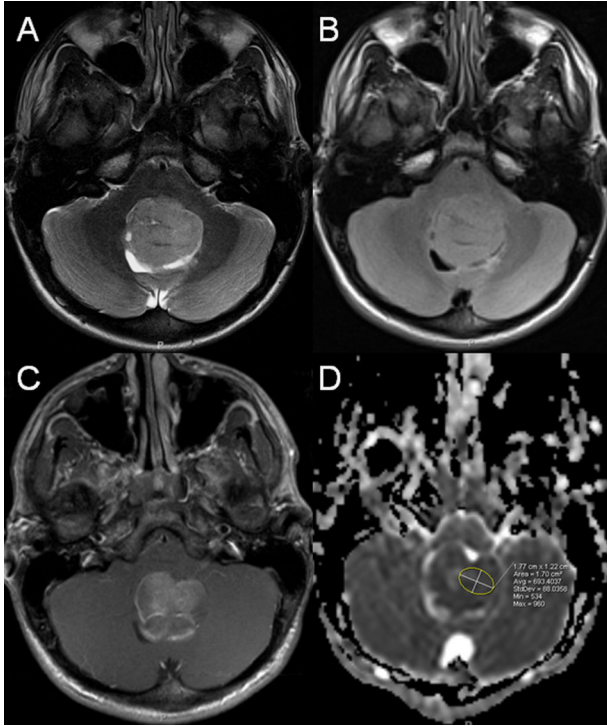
Fifteen-year-old male with classic MB. A: Axial T2-weighted and (B) FLAIR images show a large, midline, solid mass with heterogeneous, predominantly hyperintense signal. C: axial contrast enhanced T1-weighted image at the same level as (A) and (B) demonstrates mild heterogeneous enhancement. D: ADC map corresponding to (A)–(C) reveal matching low ADC values (hypointense) compared with normal cerebellar tissue representing decreased diffusion.
